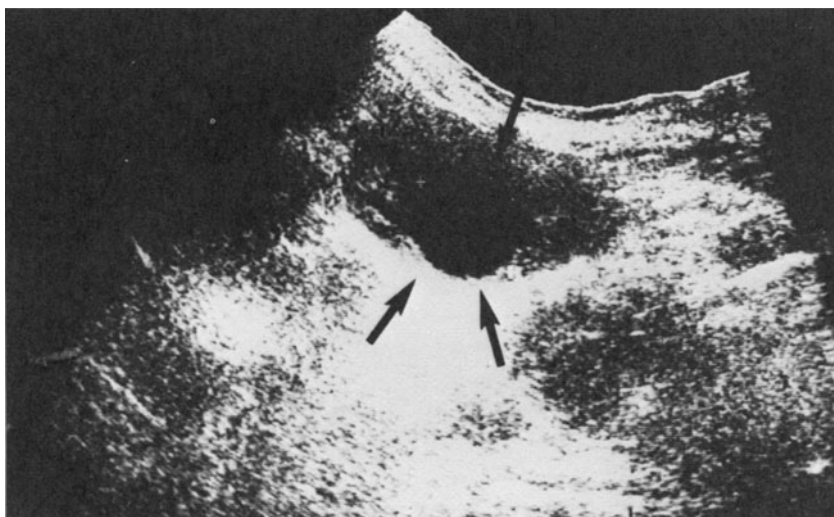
Renal Cyst. Criteria on Ultrasonography include echo free lesions, sharp interfaces and enhanced transmission of sound through cystic space.
